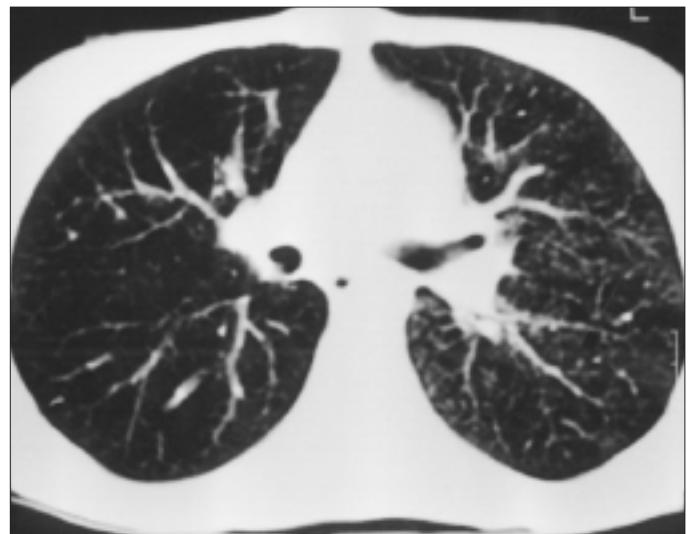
Thorax CT of the case 2 after therapy
